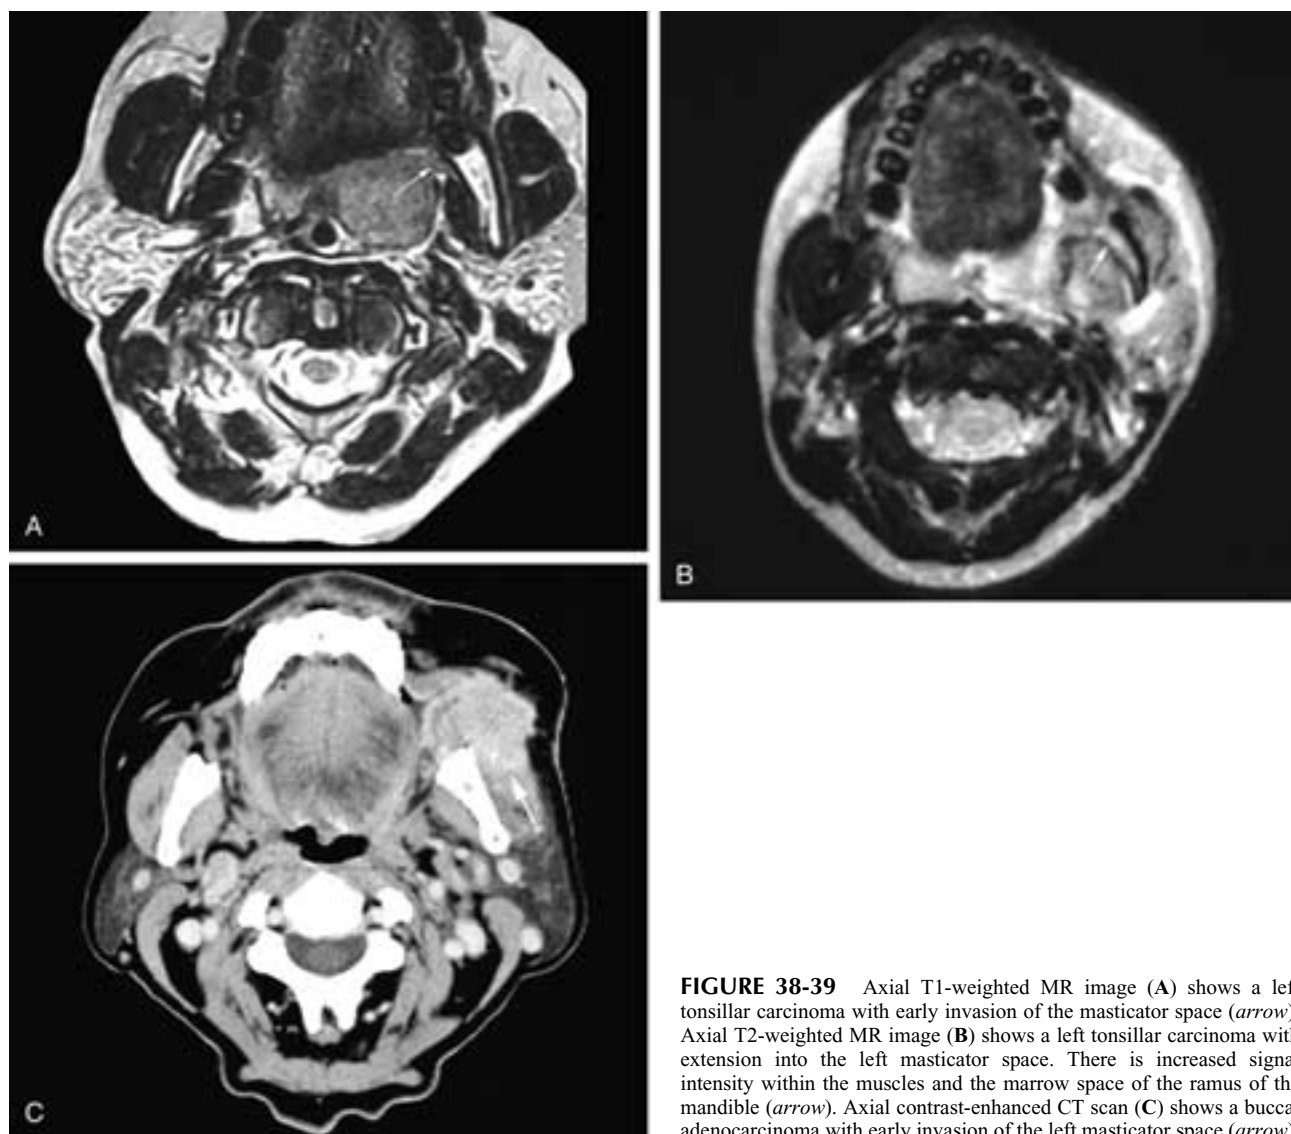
Axial T1-weighted MR image (A) shows a left tonsillar carcinoma with early invasion of the masticator space (*arrow*). Axial T2-weighted MR image (B) shows a left tonsillar carcinoma with extension into the left masticator space. There is increased signal intensity within the muscles and the marrow space of the ramus of the mandible (*arrow*). Axial contrast-enhanced CT scan (C) shows a buccal adenocarcinoma with early invasion of the left masticator space (*arrow*).
